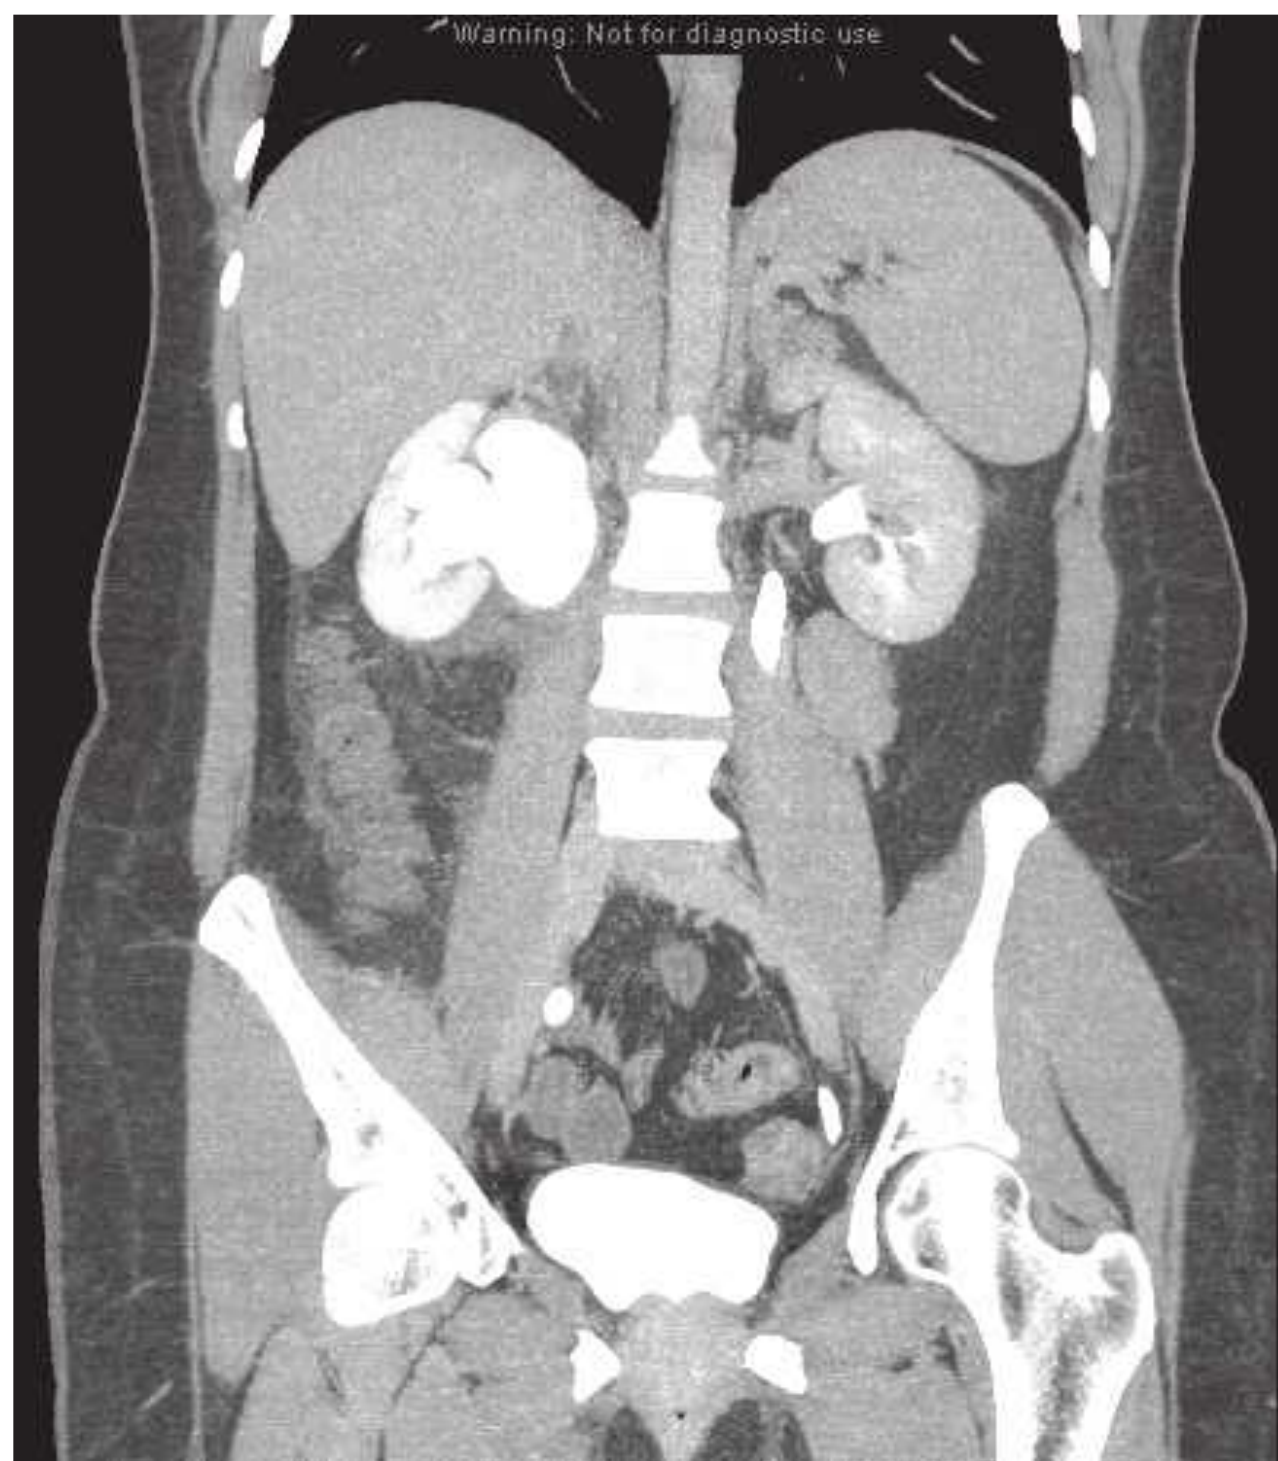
A coronal computed tomography image of the abdomen showing a ureteropelvic junction obstruction with hydronephrosis of the patient's right kidney on delayed contrast images with a normal left-sided collecting system.
